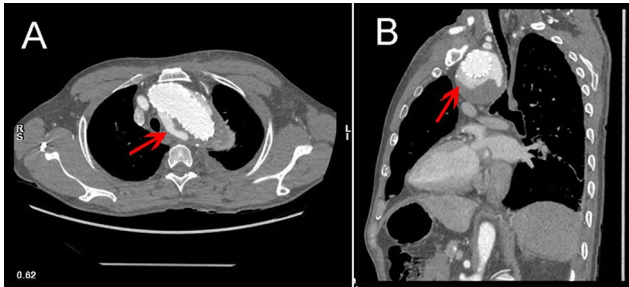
CTA showed proximal endoleak in a case the third month after discharge
